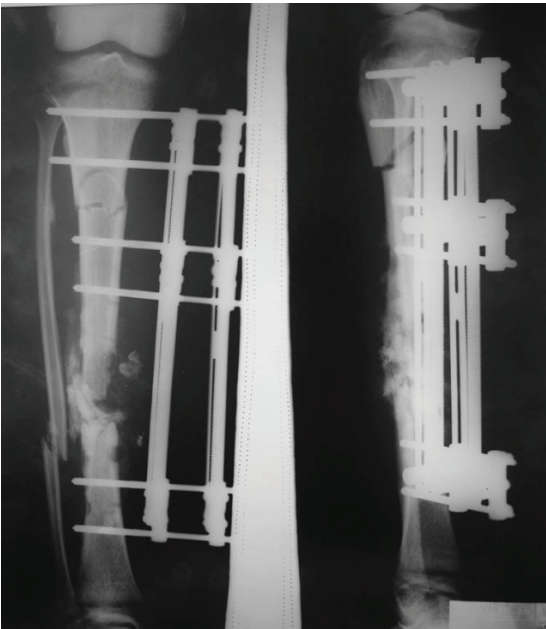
Anteroposterior radiograph of a 22-year-old man who sustained comminuted fractures of middle-distal tibia and whose fibula had an infected tibial nonunion. It shows removal of the internal fixations, eradication of the necrotic bone and tissues, and application of the 3-segment unilateral external fixator. The wounds were packed with iodoform gauze additionally.
